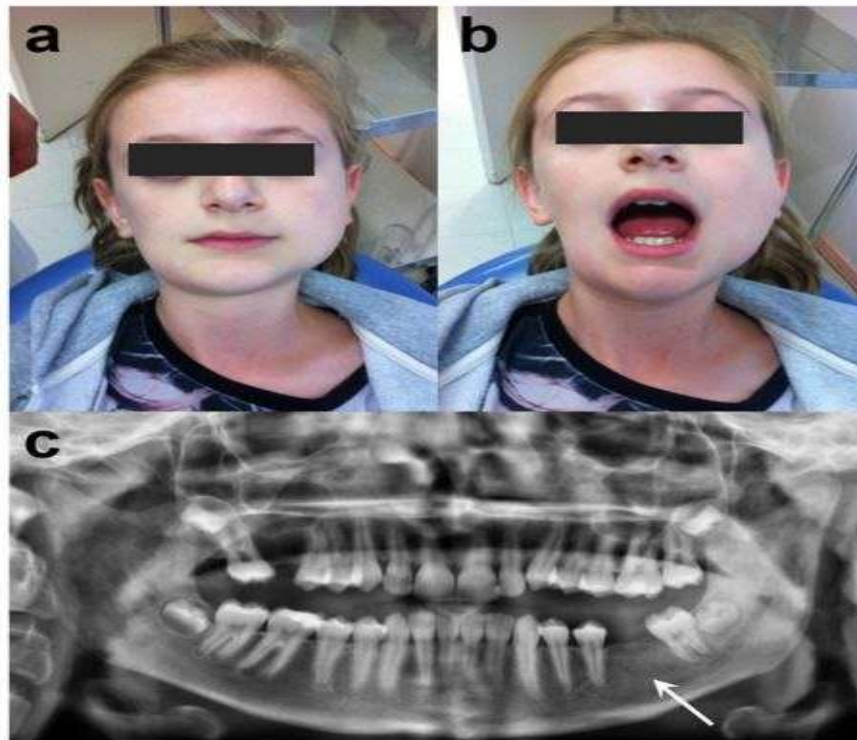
Initial presentation of patient: (a) frontal view of the patient, (b) limited mouth opening of 25 mm inter-incisor distance, (c) panoramic radiograph showing diffuse radiopacity in the left mandibular bone (white arrow).
